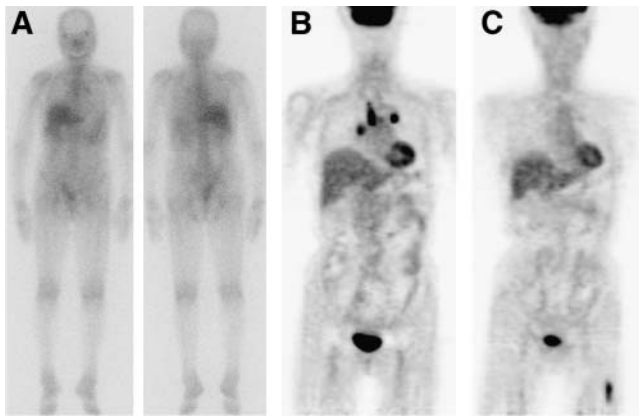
^{67}Ga scintigraphy and ^{18}F -FDG PET images of 70-year-old woman with pulmonary and extrapulmonary sarcoidosis (patient 10 in Table 1). (A) Anterior and posterior ^{67}Ga whole-body images show no abnormal uptake. (B) ^{18}F -FDG PET image shows increased uptake at mediastinal and bilateral hila. (C) Increased uptake is also observed at left upper thigh on ^{18}F -FDG PET image.
